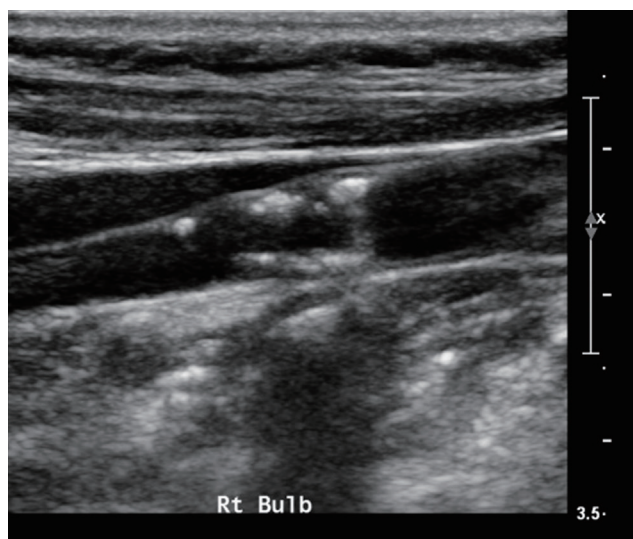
Ultrasound (US) example of an irregular plaque. The US image shows a large amount of irregular-appearing heterogeneous plaque with multifocal calcification (bright areas with shadowing) in the carotid artery.
